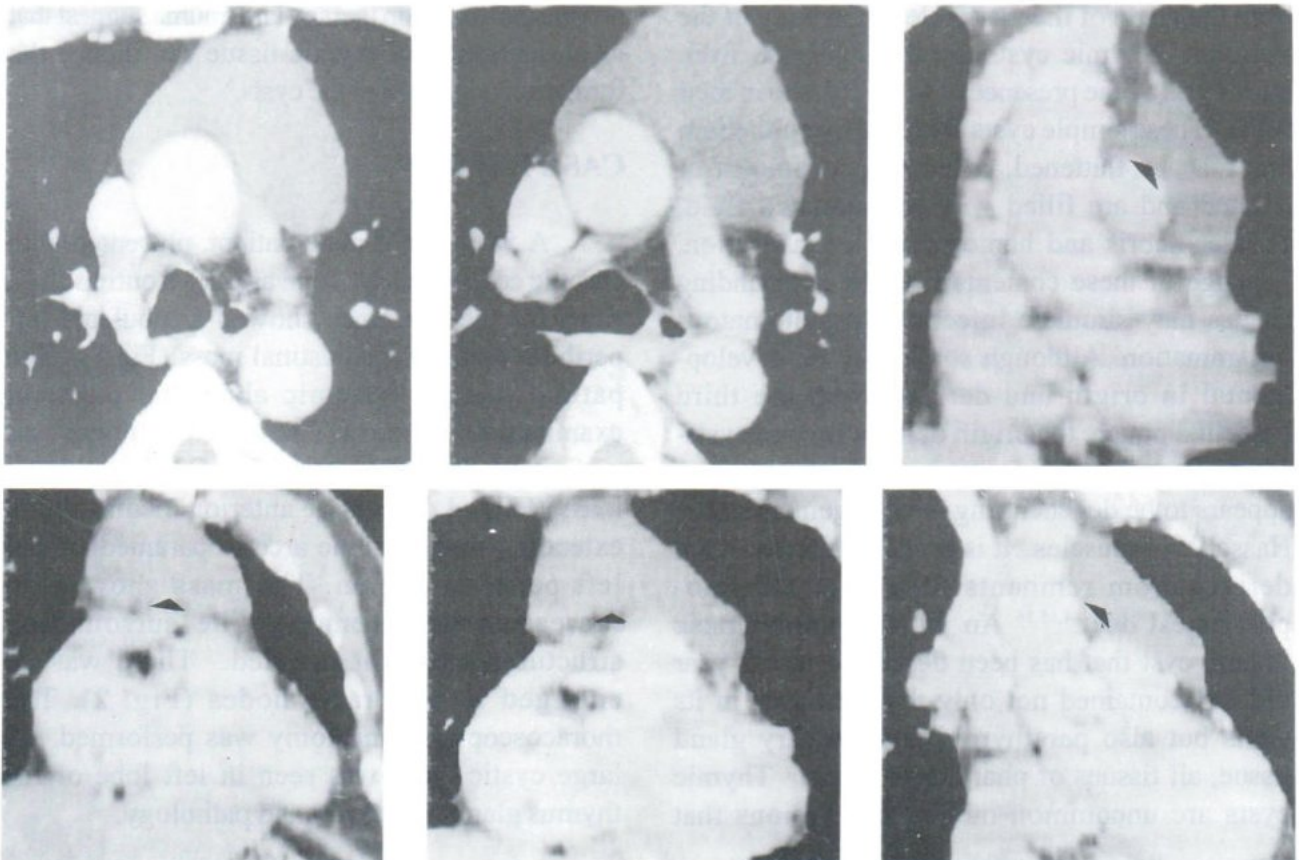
Axial, coronal and oblique coronal and oblique sagittal views spiral CT scan of the thymic cyst showed a sharply well defined border cystic lesion at the anterior mediastinum, extending to the left perihilar area without invasion of the nearby structures.
